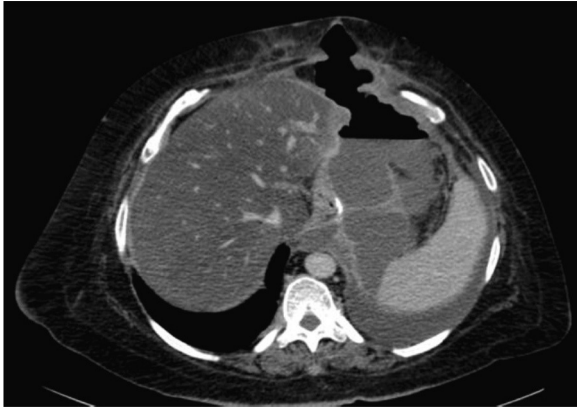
Abdominal CT with a large perigastric collection and left pleural effusion secondary to the gastric fistula.
